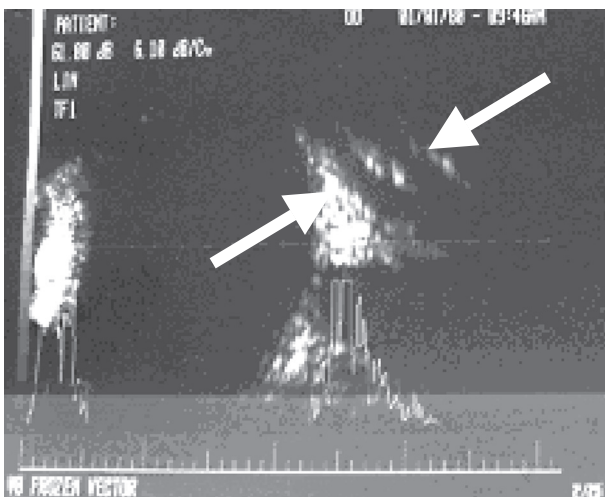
B scan ultrasound showing enlargement (arrows) of the left rectus superior muscle and levator palpebrae superioris muscle complex.
